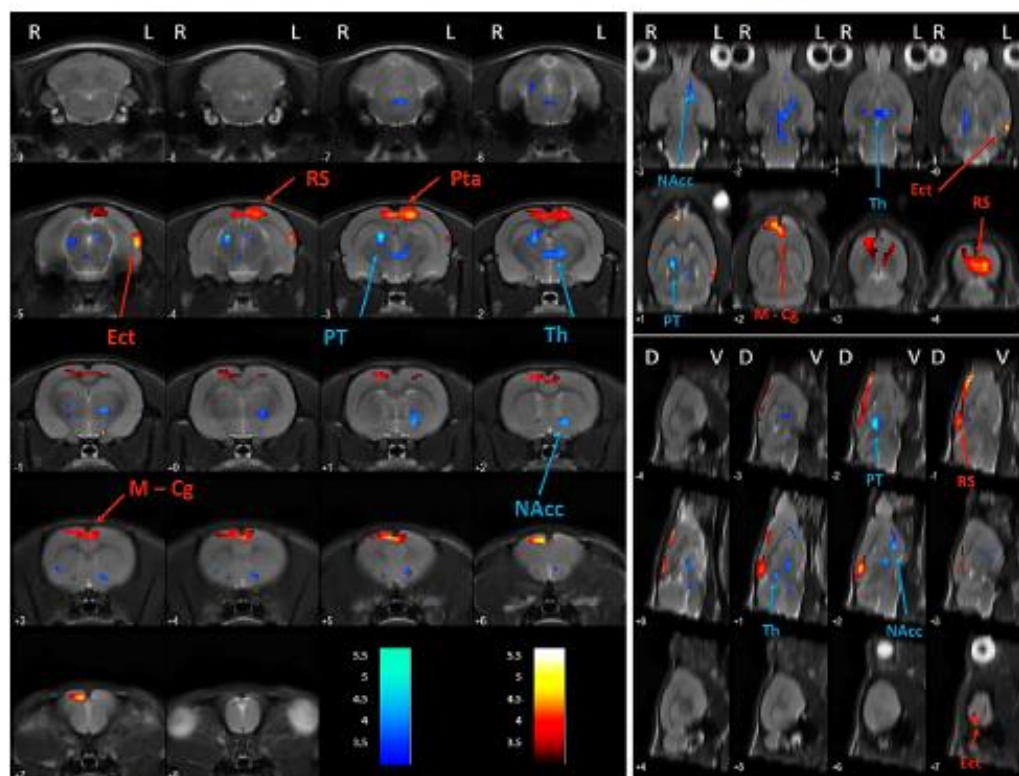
NA α -DBS effects on brain metabolism. Axial (left), coronal (upper right) and sagittal (lower right) views of the brain. Colored PET overlays on the MR reference indicate increased FDG uptake (hot colors) or decreased FDG uptake (cold colors) 1 day after the end of the stimulation in NAcc. Left (L), right (R), dorsal (D), ventral (V).
